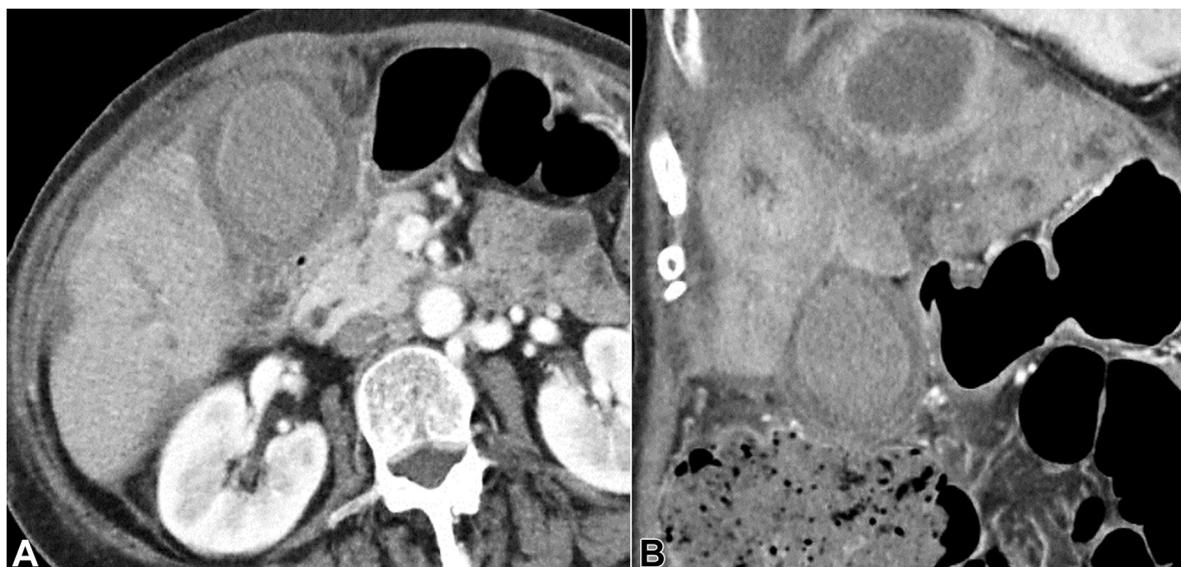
CT revealed acute cholecystitis, ascites, and intrahepatic cholangiocarcinoma.
